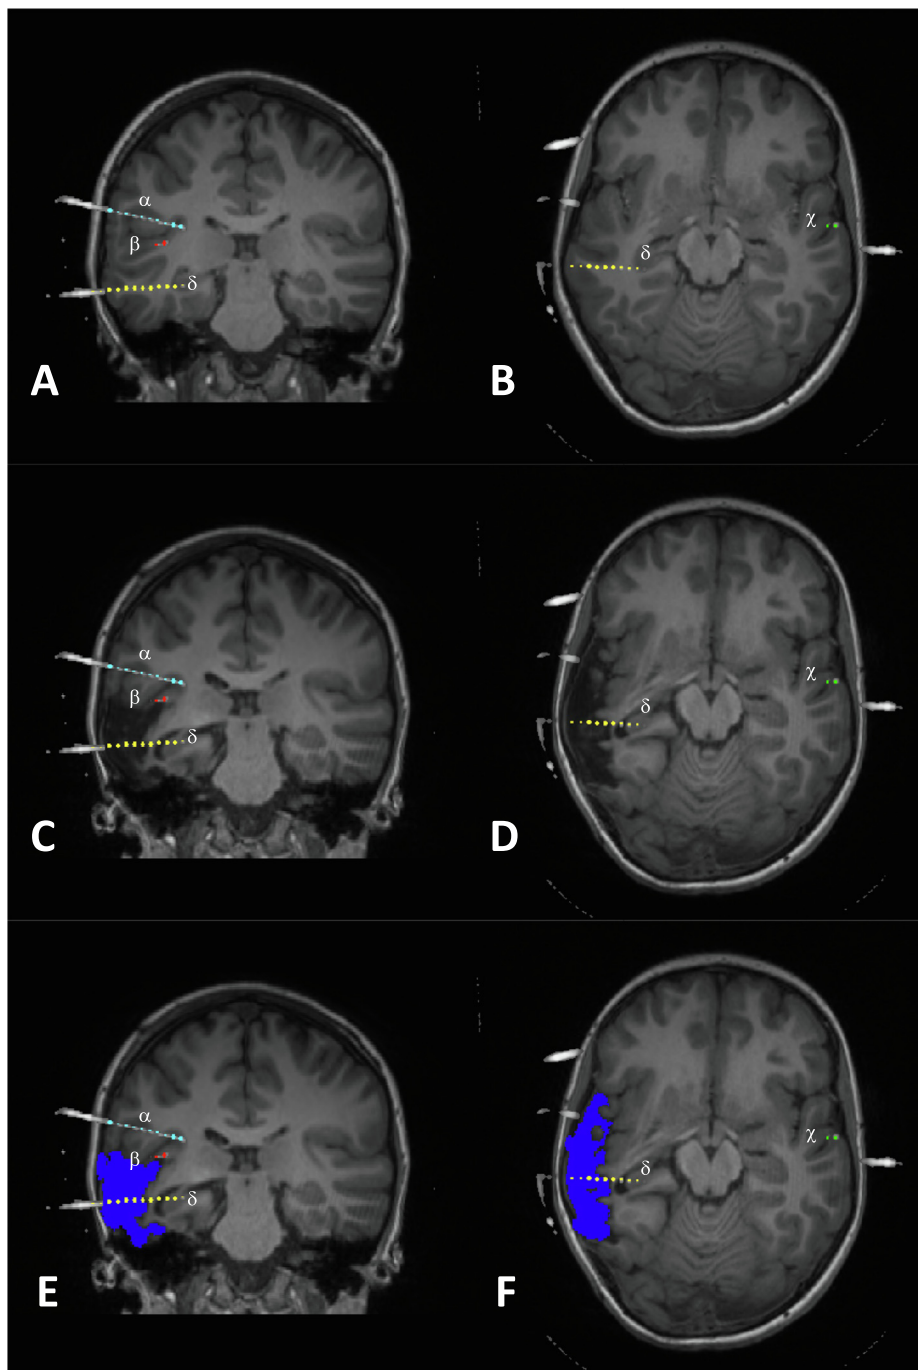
Co-registration of pre- and post-operative magnetic resonance images with stereoelectroencephalography (SEEG) electrodes' computerised tomography images and segmentation images. Magnetic resonance imaging (MRI) reconstructions of the resected seizure onset zone (SOZ) based on SEEG recordings, with co-registered coronal (left hand side panels) and axial (right hand side panels) scans. Four separate depth electrodes can be seen: electrode α targeting the right parietal operculum (light blue), electrode β targeting the right posterior superior temporal gyrus (STG) (red), electrode χ targeting the left STG (green) and electrode δ yellow targeting the right posterior hippocampus (yellow). Each electrode contact point is represented by a circle. Starting from the deepest one, contacts for each electrode are labelled numerically. In this example, pre-operative SEEG ictal recordings revealed a putative SOZ in the right STG (particularly the temporal operculum), represented by contacts β [6, 7, 8, 9, 10] (A and B). These contacts are subsequently resected, as indicated in the post-operative scans (C and D). The resection area is then manually delineated to calculate the proportion of SOZ contacts resected, with the resection cavity marked in dark blue (E and F). In this case, 50% of the SEEG-defined SOZ contacts have been resected (note that other electrodes in the SEEG-defined, putative SOZ cannot be seen in these MRI planes. These MRI planes depicting 4 electrodes have only been chosen for representation purposes).
